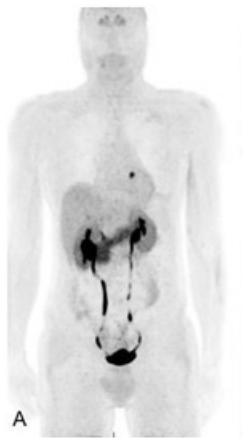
Whole-body ^{18}F -FDOPA Maximum Intensity Projection acquired on a Biograph mMR PET/MRI platform (Siemens, Erlangen, Germany).
